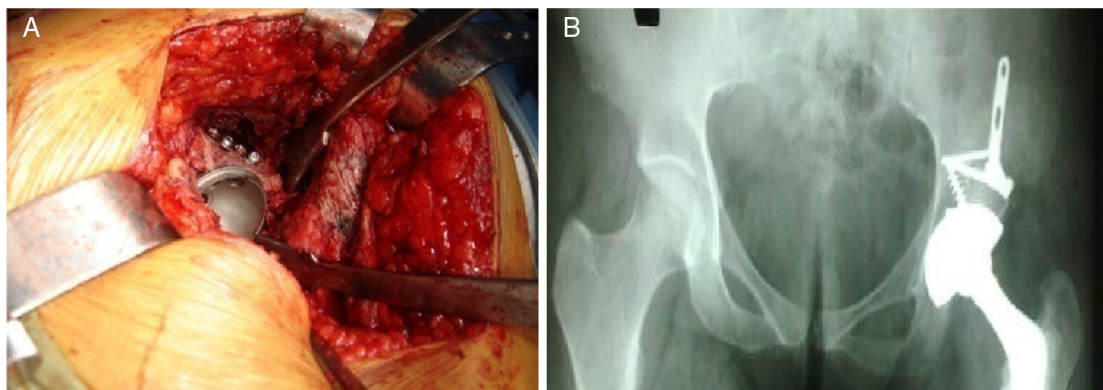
Rigid fixation of the autograft for acetabular reconstruction with Allis plate, showing intraoperative image (A) and pelvic X-ray in post-operative anteroposterior view, showing acetabular reconstruction (B).
